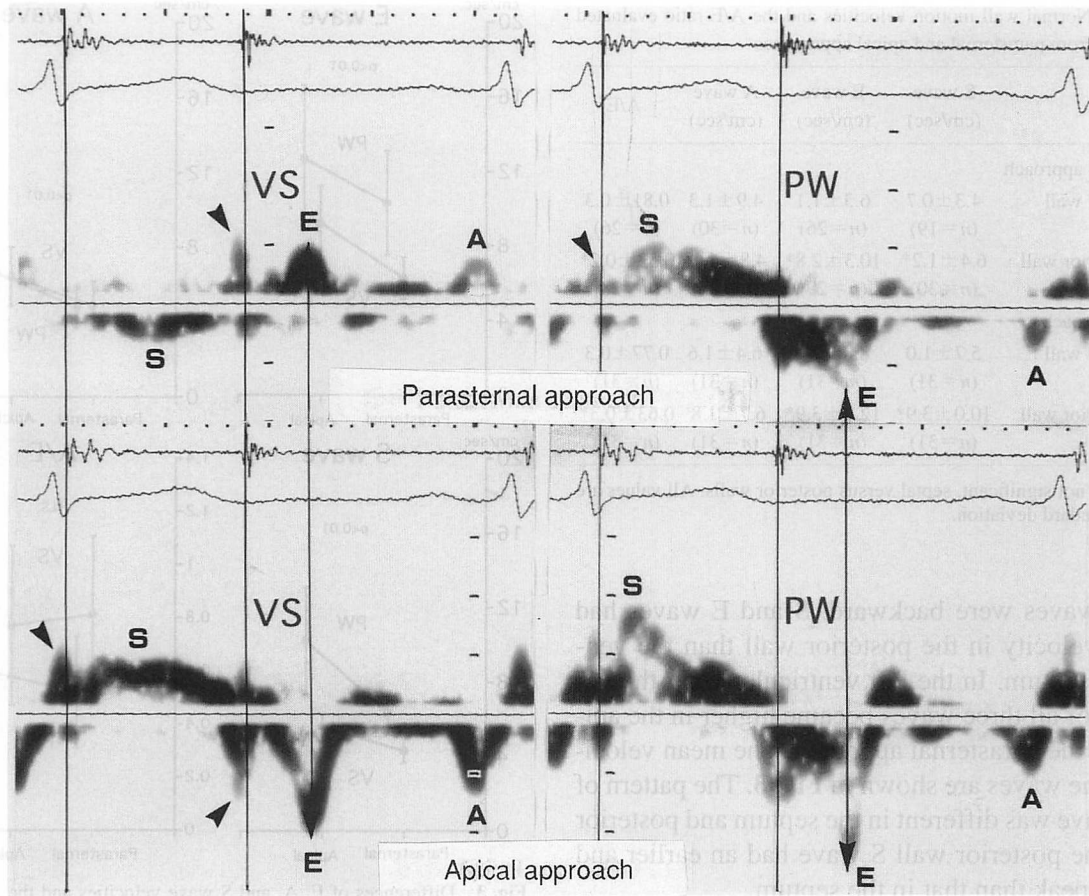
Representative pulsed Doppler echocardiograms from a 27-year-old normal subject
